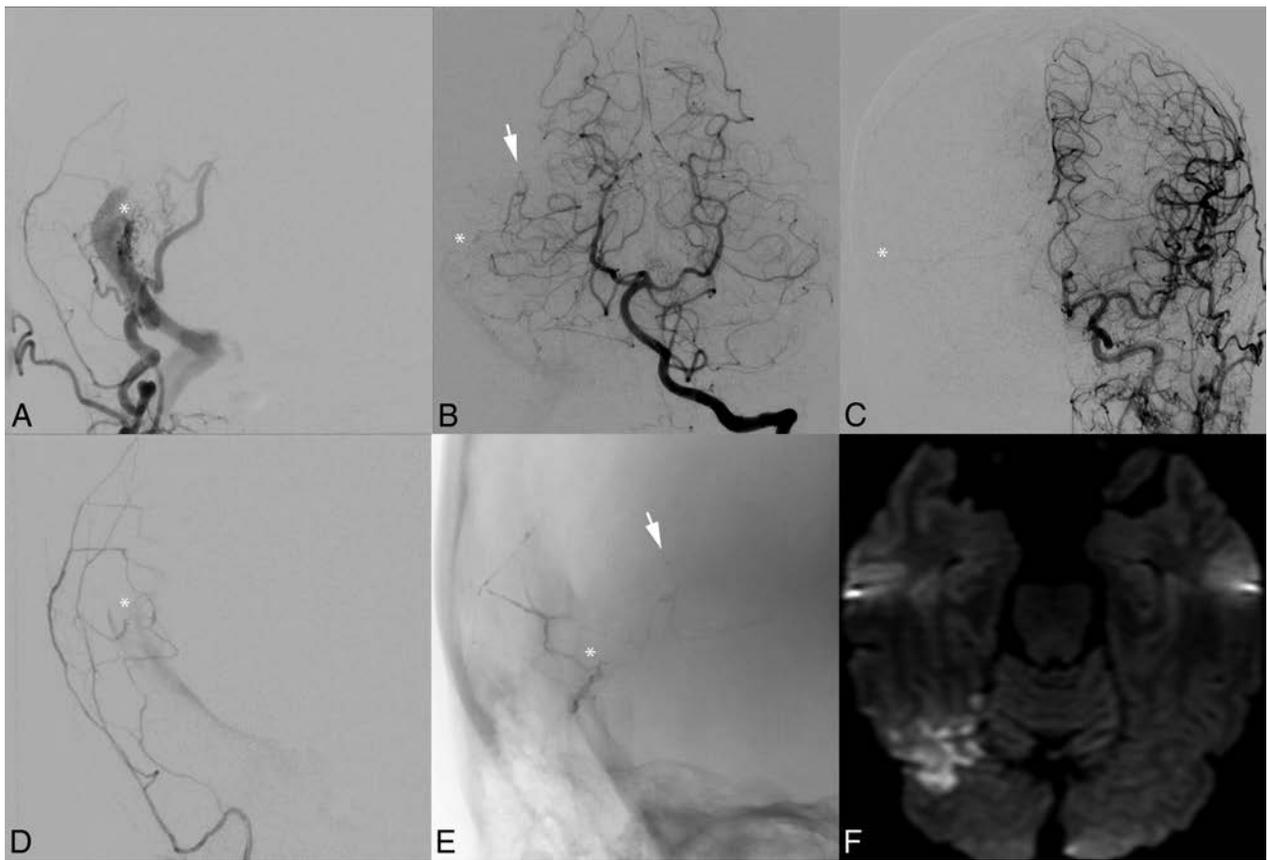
Postembolization infarction due to Onyx migration into a pial artery. A middle-aged woman with severe pulsatile tinnitus underwent endovascular therapy for a right transverse-sigmoid sinus junction Borden-Shucart grade I DAVF supplied principally by the middle meningeal and occipital arteries (A) and secondarily by the ipsilateral middle temporal artery (B) and tentorial branches from the contralateral middle meningeal artery (C). The fistula site is designated by a *white asterisk*. The fusiform gyrus branch of the middle temporal artery is indicated by a *white arrow*. Superselective injection of the right middle meningeal artery demonstrates the fistula site before embolization (D). Midembolization x-ray (E) demonstrates Onyx in the middle meningeal artery, fistula site, and refluxed into the pial fusiform gyrus branch of the middle temporal artery. The extent of reflux had not been evident on real-time intraprocedural blank roadmap imaging. DWI later the same day (F) demonstrates a fusiform gyrus infarction.
